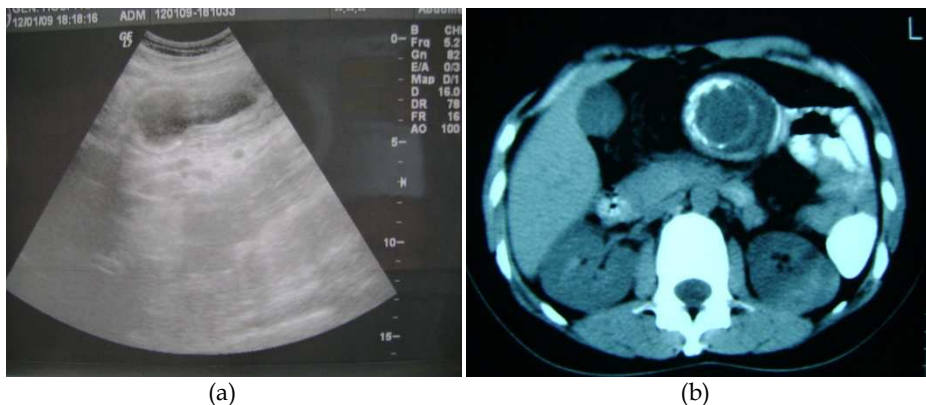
(a) Abdominal ultrasound image, showing the intussuscepted appendiceal mucocele mentioned in previous figures, in a longitudinal cross section. (b) Abdominal CT scanning image, showing the calcified base of the same appendiceal mucocele intussuscepted into the lumen of the transverse colon. Pathognomonic “bowel-within-bowel” configuration. (From our clinic’s photo archive).
